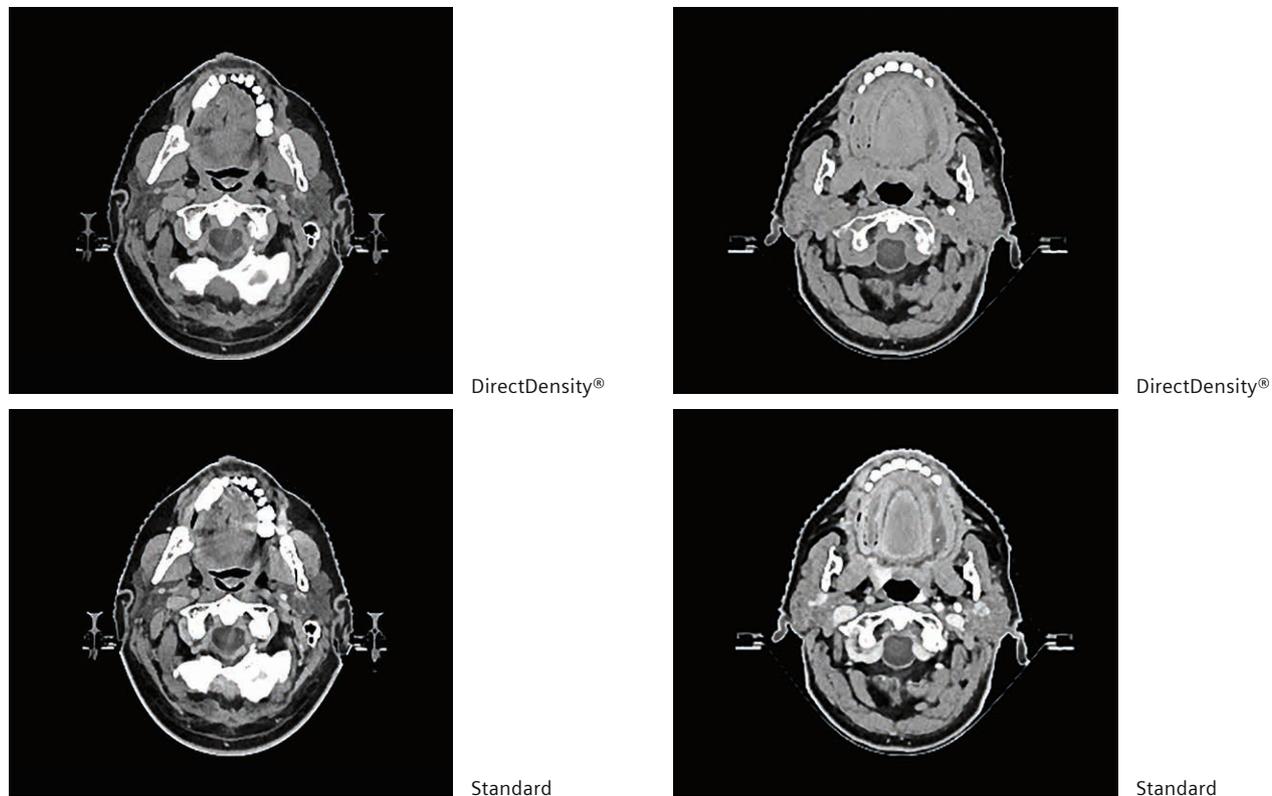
CT images of a head & neck case from the same 120 kV acquisition. Courtesy of MAASTRO Clinic, Maastricht, Netherlands. Window level: C = 40, W=300.
